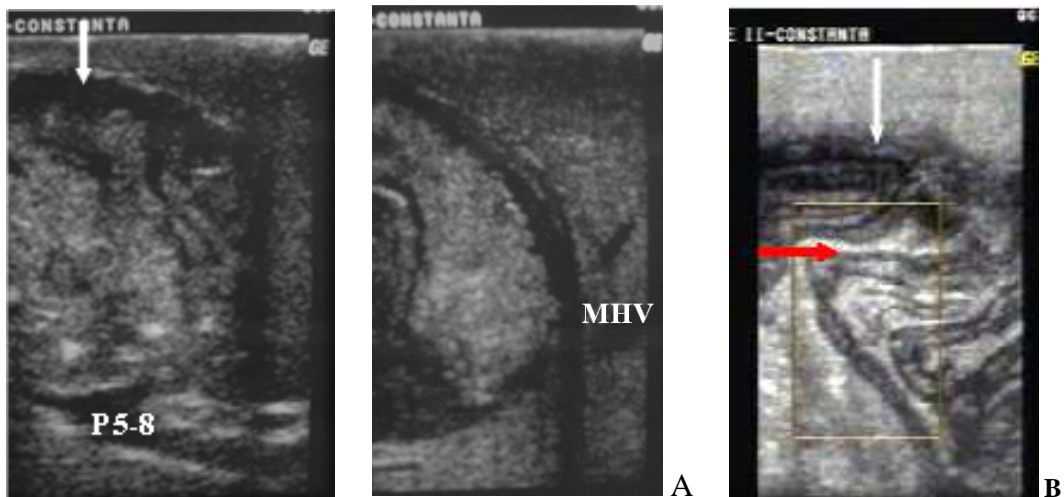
IOUS in infected hydatid cyst. A. IOUS in a 64 year-old patient locates the hydatid cyst situated in segments 5 and 8, in relationship with the anterior portal branch of the right portal vein (P5-8) and medial hepatic vein (MHV). B. Infected hydatid cyst, with detached and manipulated hydatid membrane (horizontal arrow). The vertical arrows indicate the level of ultrasound guided hepatotomy.
